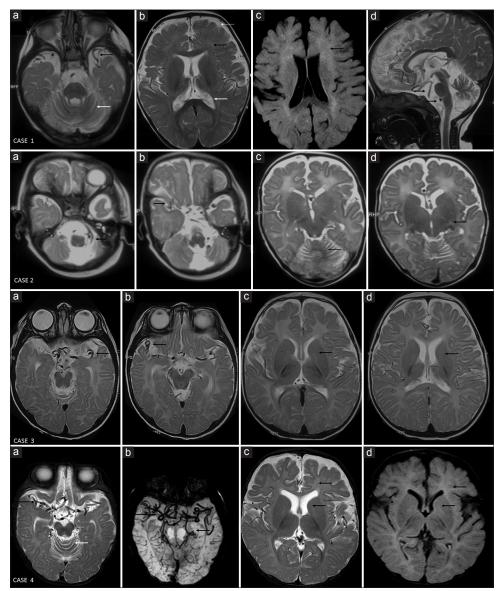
(a-d) Magnetic resonance imaging of the brain findings in our series of patients with Menkes disease. Case 1 (a-d): Magnetic resonance imaging of the brain at 14 months - T2 axial image (a) shows cerebellar volume loss (white arrow) and tortuous middle cerebral arteries (black arrow). Posterior vasculature also appears tortuous (black arrows in d). T2 axial and T2 FLAIR images (b and c) shows abnormal myelination (black arrows) and cerebral volume loss as evidenced by ventricular and anterior subarachnoid space prominence (white arrows in b). Case 2 (a-d): Magnetic resonance imaging of the brain at 2 months - T2 axial images show tortuosity of posterior (black arrow in a) and anterior vasculature (black arrow in b), cerebellar volume loss (black arrow in c), and delayed myelination of posterior limb of internal capsule (black arrow in d) corresponding to appearance at birth. Case 3 (a-d): Magnetic resonance imaging of the brain at 8 months - T2 axial images showing marked tortuosity of the anterior vessels (black arrows in a and b). Delayed myelination corresponding to <6 months was observed (black arrow in c and d) in view of absent myelination of anterior limb of internal capsule. Case 4 (a-d): Magnetic resonance imaging of the brain at 9 months - T2 axial images (a) and susceptibility weighted imaging (b) show markedly tortuous anterior and posterior vessels (black arrows). Mild superior cerebellar volume loss is also seen (white arrow in a). T2 axial (c) and T2 FLAIR (d) images show features of hypomyelination with absent myelination of anterior limb of internal capsule and increased signal of deep white matter (black arrows)
